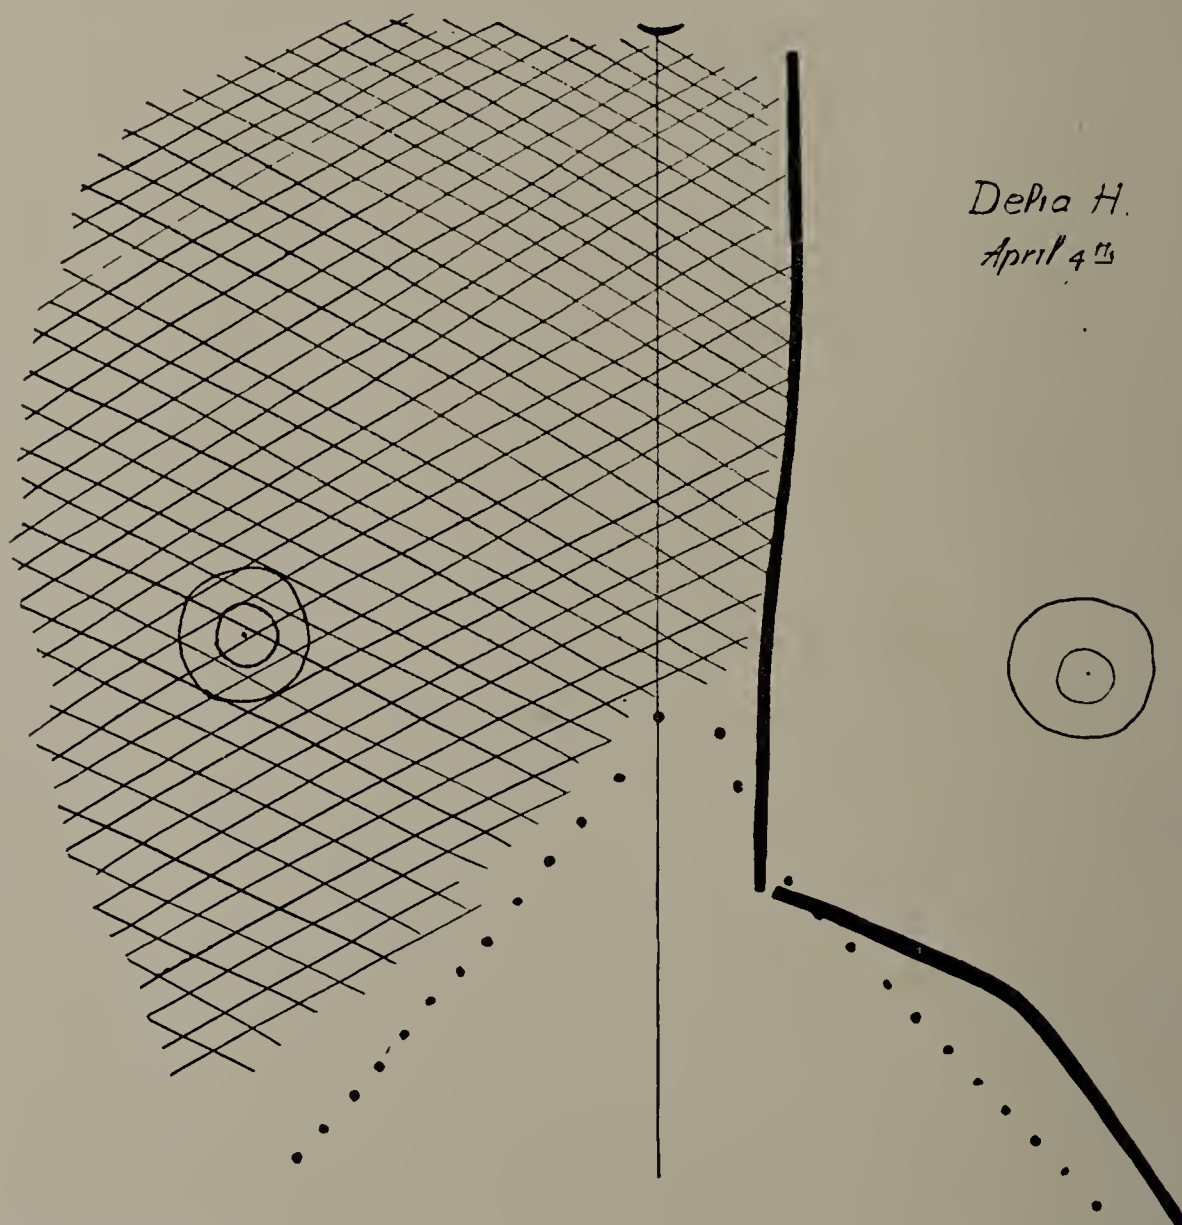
Delia H. First X-ray tracing. Pneumothorax of left side; tuberculosis of right side. Whole of left side abnormally bright; right side very dark; the full dark, nearly perpendicular line gives the border of the light area; the dotted line indicates the costal border. The diaphragm line is seen to be very low down in the chest on the left side; this side of the muscle had little movement during respiration, and this movement was chiefly at the median end, as if the motion were imparted to it from the right half of the diaphragm. The outline of the contracted left lung was not distinctly seen, although in other cases I have been able to follow it. (One-third life size.)
